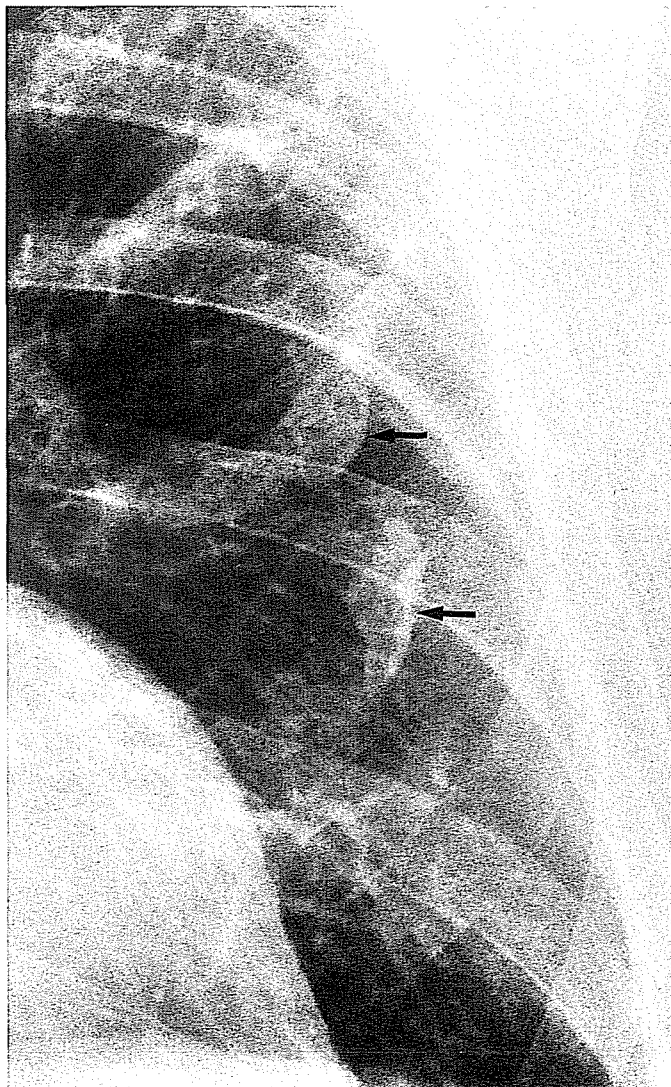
Radiograph showing en face pleural calcifications (arrows).
